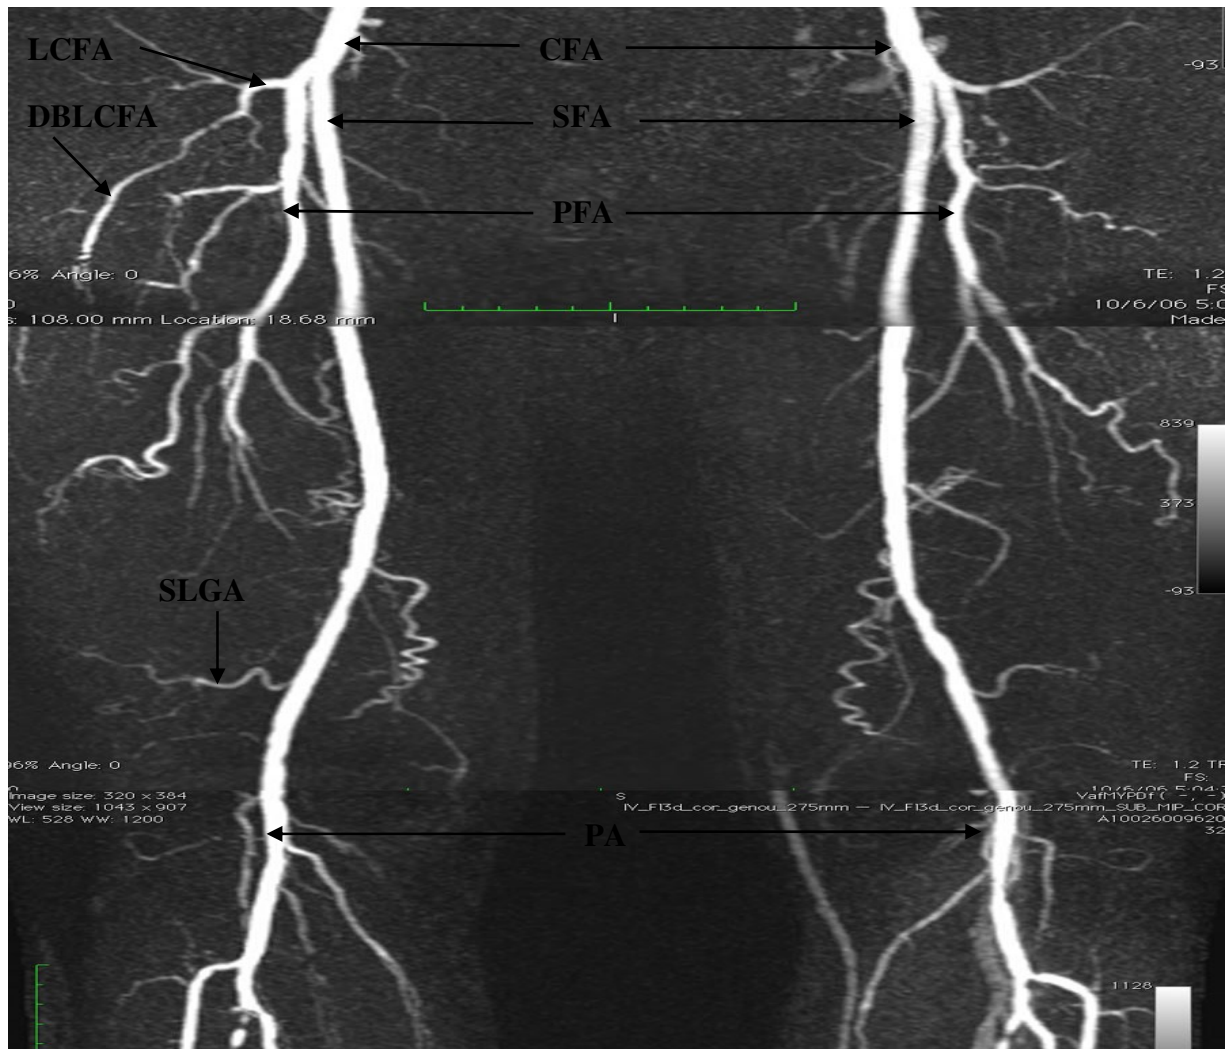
A 3D MIP (maximum intensity projection) of contrast-enhanced MRI data showing arteries of the anterior thigh in right and left limbs.
